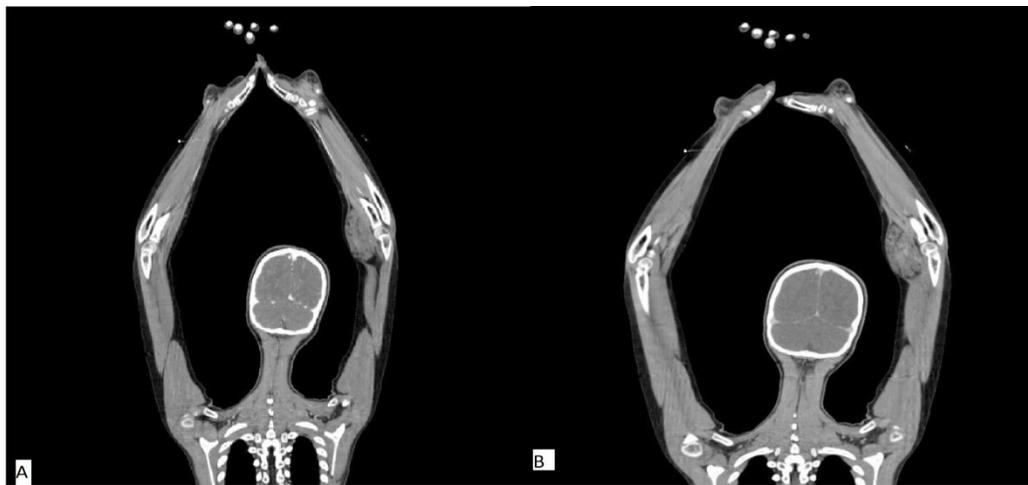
(A): Coronal plane in a contrast enhanced CT in the arterial phase showing no enhancement of the left elbow mass. (B): Coronal plane showing a discrete enhancement of the mass in the venous phase.
